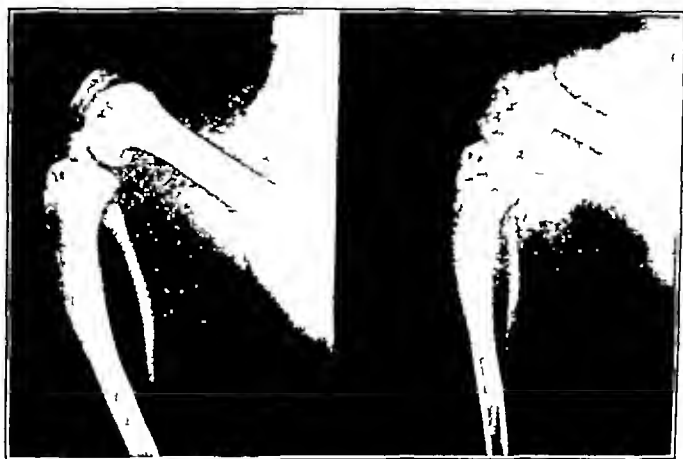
Roentgenograms of lower extremity. Left. Control no rickets. Right. Ferric chloride diet advanced active rickets.
